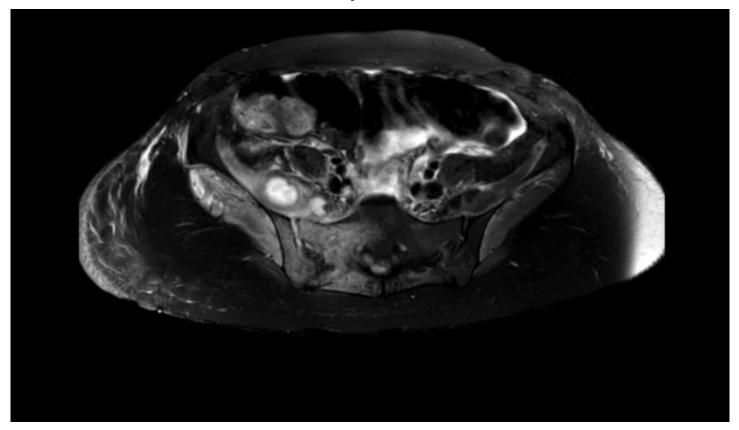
Cross-sectional T1 weighted MR imaging showing the abscess tracking over the sacroiliac joint to the muscles of the back
